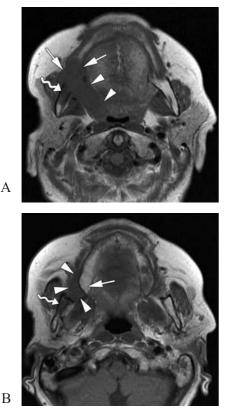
Axial plain T1-weighted MR images in a patient suffering squamous cell cancer of the right retromolar trigone.
